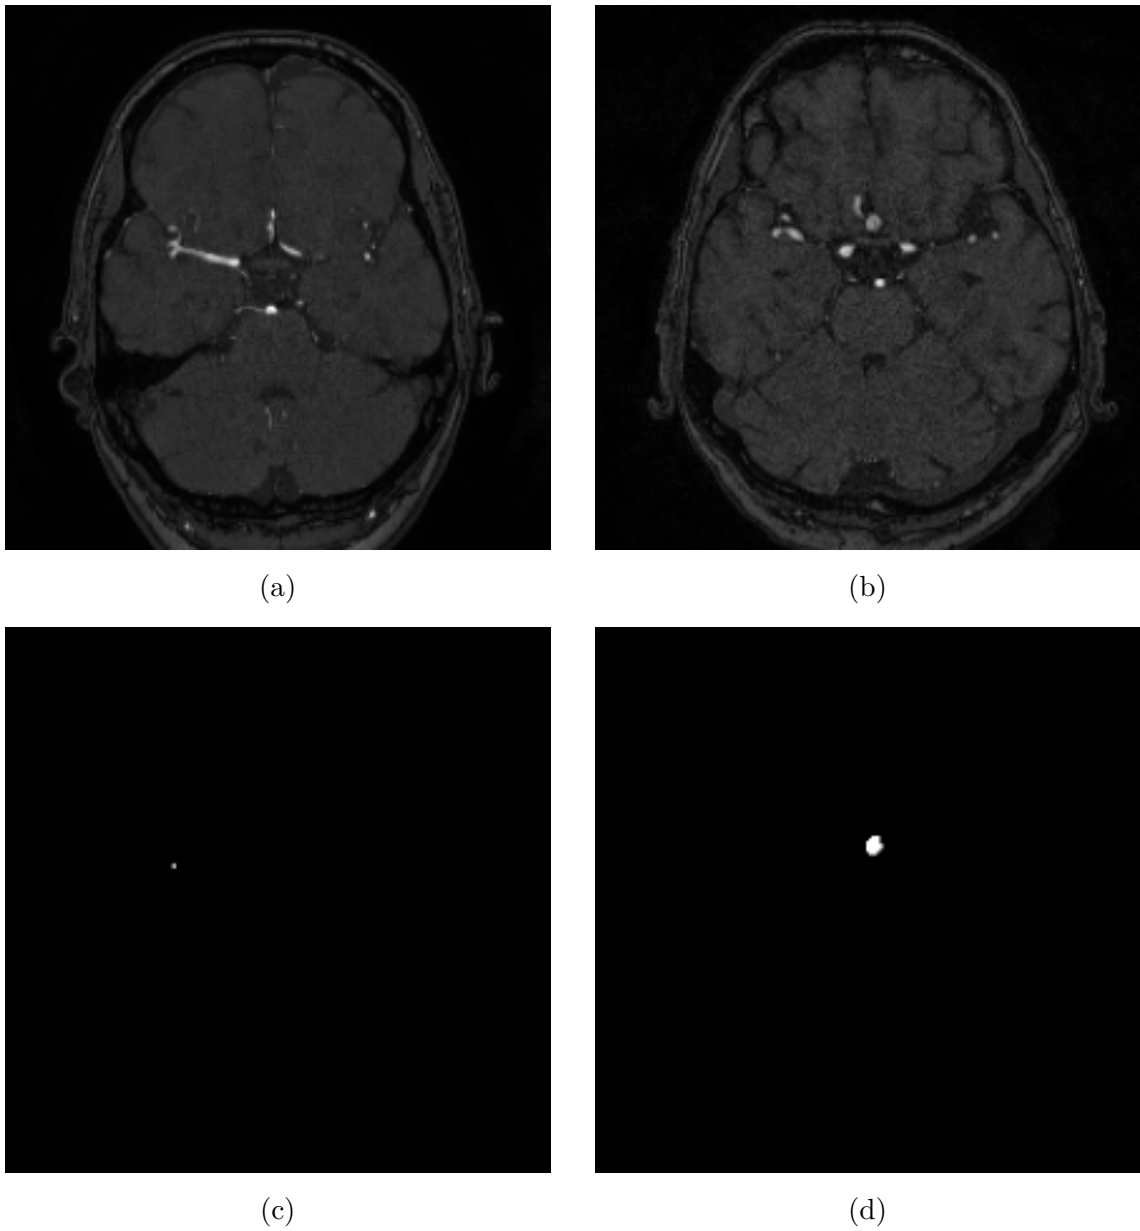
This figure shows examples of images and their references. Images (a) and (b) show slices of the TOF-MRI images. Pictures (c) and (d) are their groundtruth masks.
